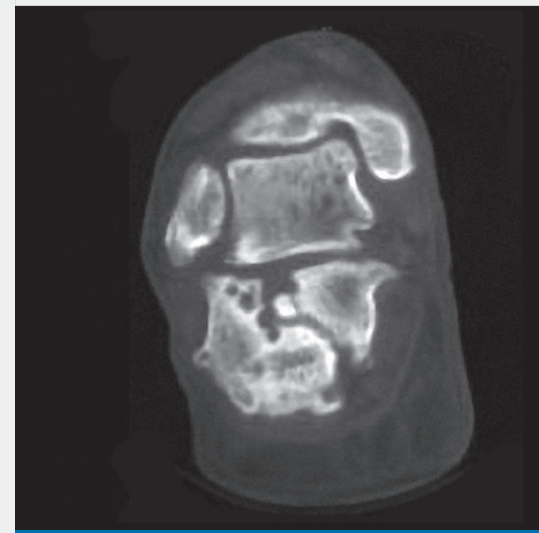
Foot CT of the non-union.
